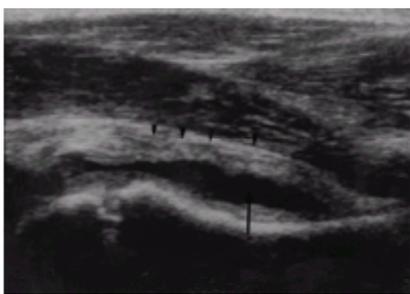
Fluid in the hip joint. Ultrasonography shows anterior accumulation of fluid (arrow) with distension of the joint capsule and synovial thickening (arrowhead).
